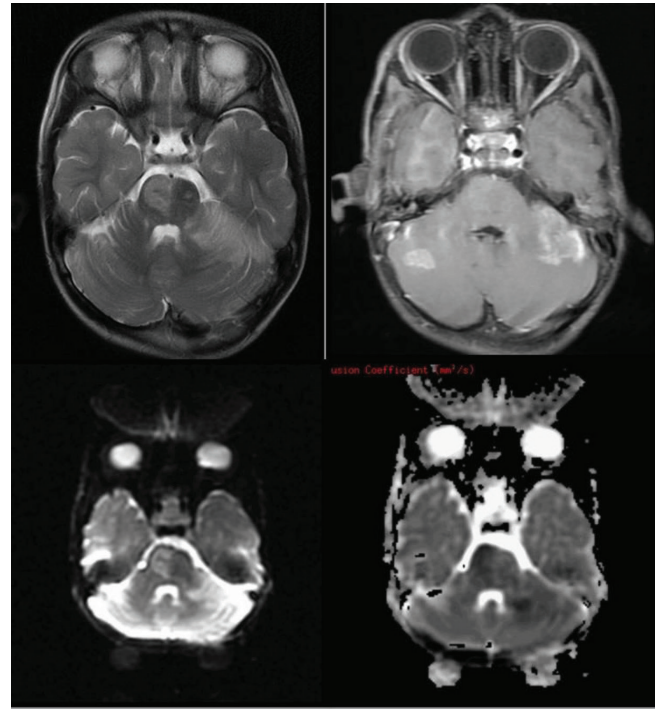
Axial T2/T1C/DWI/ADC: showing multifocal patchy areas of altered signal changes appearing hyperintense on T2/FLAIR noted involving pons, bilateral cerebellar hemispheres and left cerebellar peduncle. These areas show faintly restricted diffusion on DWI with corresponding defect on ADC. Case of viral CNSI
